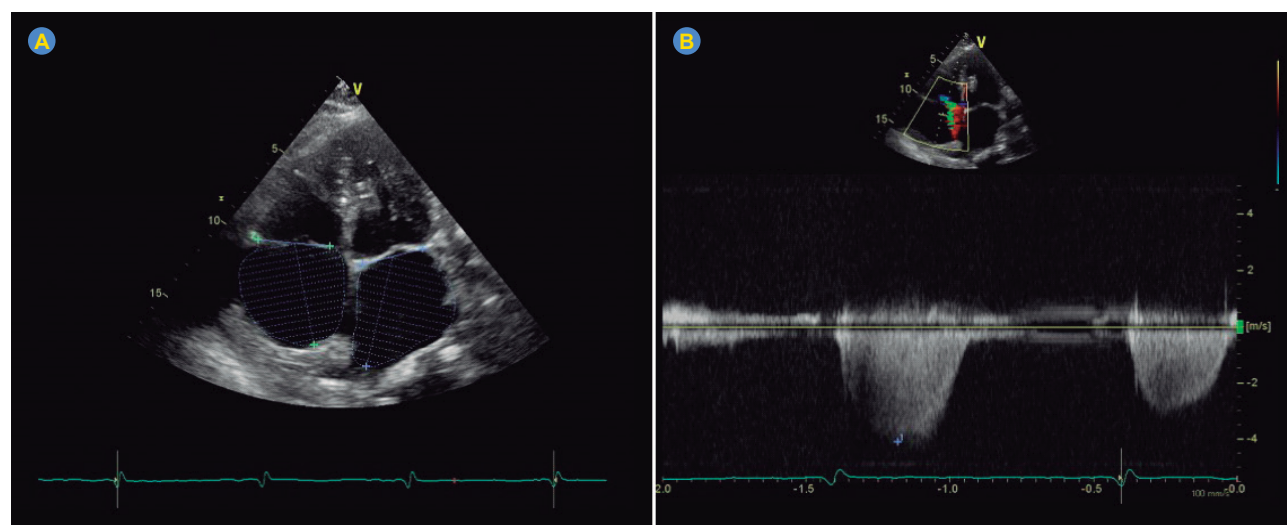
Transthoracic echocardiogram demonstrating dilated right cavities and left atrium (A); mild to moderate tricuspid regurgitation, with an estimated pulmonary artery systolic pressure (ePASP) of about 82 mmHg (B).
